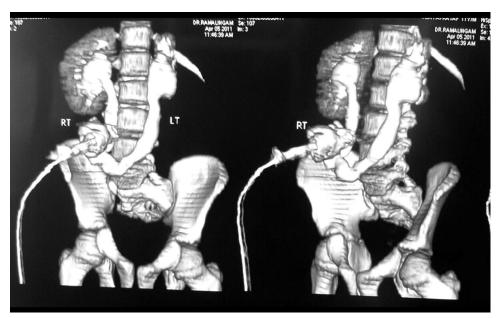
CT urogram showing the conduit and both kidneys (note the thin parenchyma in the left kidney).
